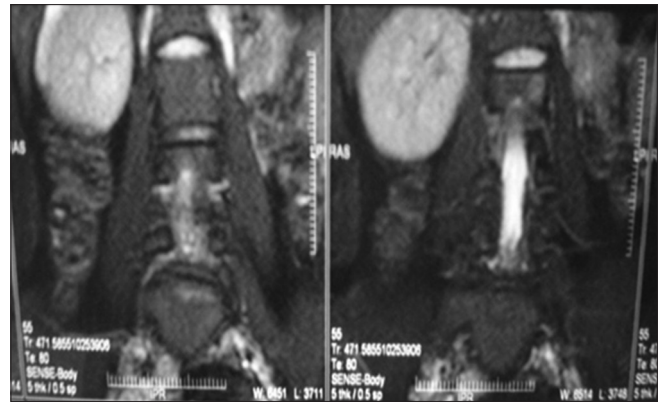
Magnetic resonance imaging abdomen showing absent uterus and vagina. Absent left kidney. Grade-I spondylolisthesis with bilateral spondylosis at L5-S1 level
